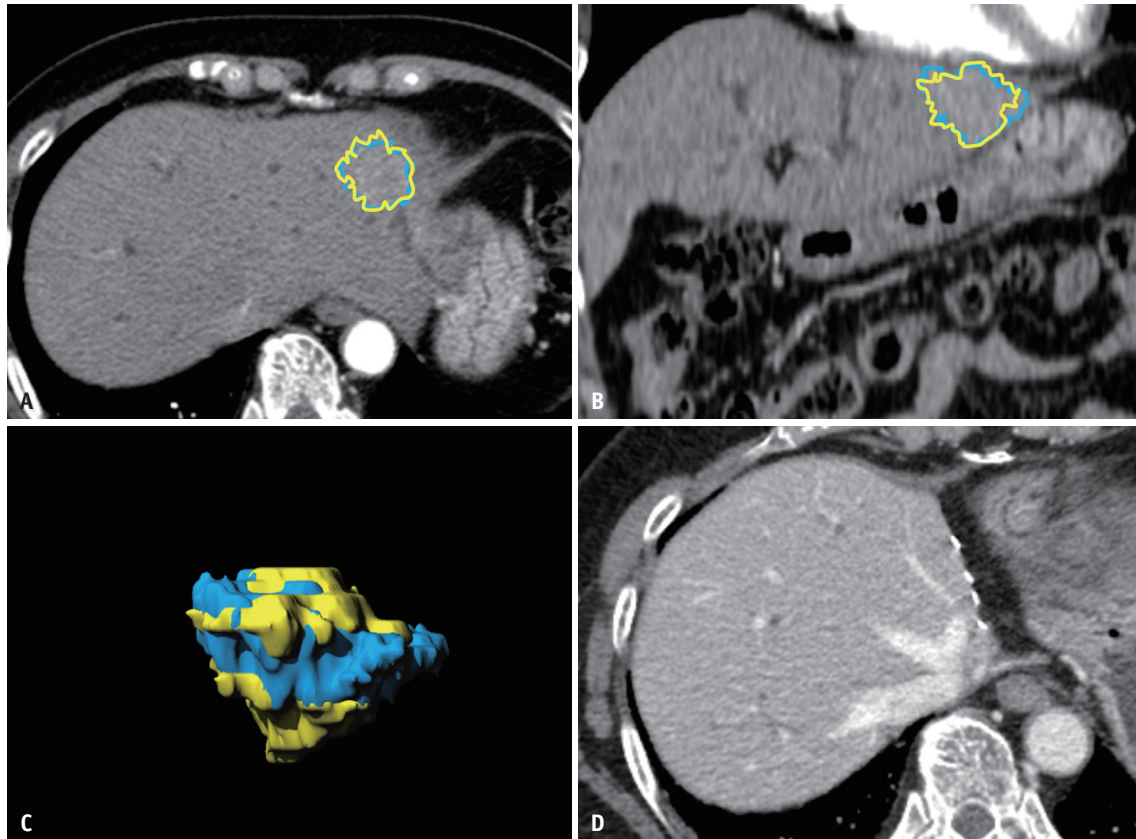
Representative case of texture analysis predicting recurrence-free survival. A 64-year-old female with cholangiocarcinoma showing arterial phase isoenhancement and slight hyperenhancement. A. Axial CT image. B. Coronal CT image. C. Volumetric reconstruction. The blue area is representative of fully automatic segmentation and the yellow area is representative of semi-automatic segmentation. The mean value of texture analysis was 89.1 and 85.8 on fully automatic segmentation and semi-automatic segmentation, respectively. The mean attenuation of 89 intrahepatic mass-forming cholangiocarcinomas was 64.6–66.3 (Supplementary Table 2, 3). D. No recurrence was observed for 77.8 months after surgical resection.
